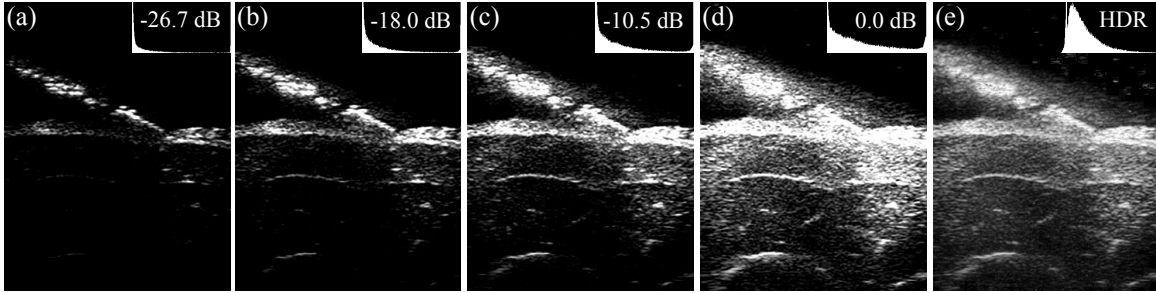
(a–d) Four of the fifteen ultrasound images acquired at various power levels, and their histograms. In low power settings, the catheter body and the skin surface have good contrast and detail; however, the deeper structures are missing. At the higher power settings, the bone surface and the deeper tissue have good detail, but the catheter and the skin are overexposed and have lost fine detail. (e) Tone-mapped high dynamic range ultrasound image. The deep tissue structures, as well as the catheter and skin details, are easily visible.
